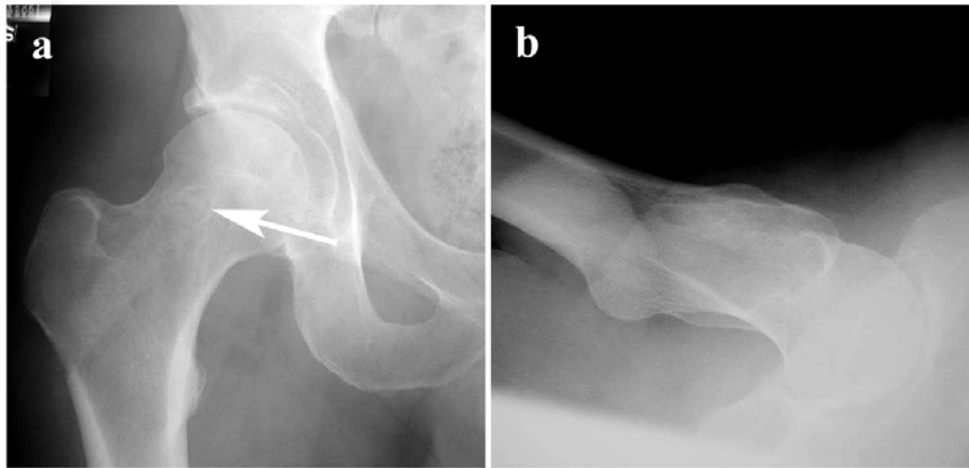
Post-op radiographs (Case 1). AP and Lateral radiographs of case 1 (a, b). Increased density seen in cored out tract filled with impacted seeded graft (arrow = site of previous body of cyst).
